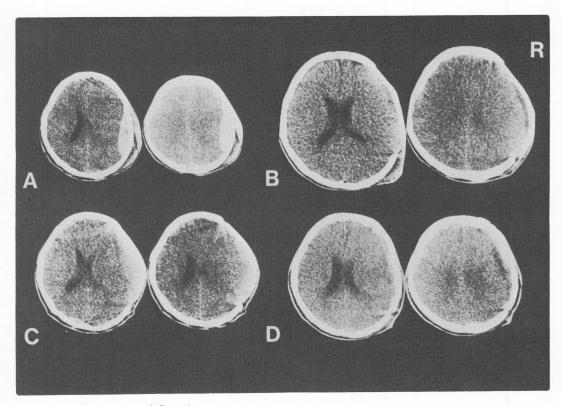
Serial CT scans of Case 2
